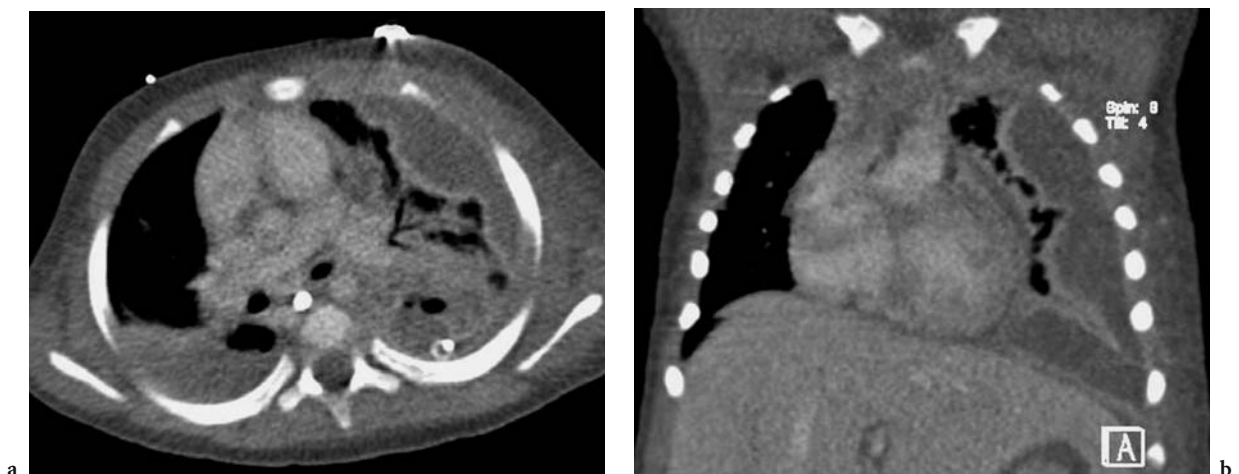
Empyema (*Enterobacter* infection) following streptococcal pneumonia in a 2-year-old child. a Contrast-enhanced chest CT scan (collimation 12×0.75 mm) shows loculated fluid collection with enhancing pleural margins in left hemithorax. Note consolidation in adjacent left lower lobe and small right pleural effusion. b Coronal reformatted image shows craniocaudal extent of empyema
